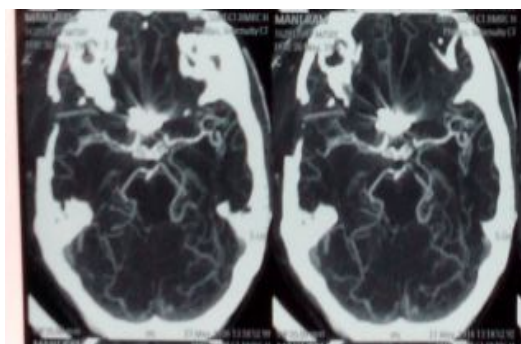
CT Angiography shows Acomm aneurysm projecting anteroinferiorly
